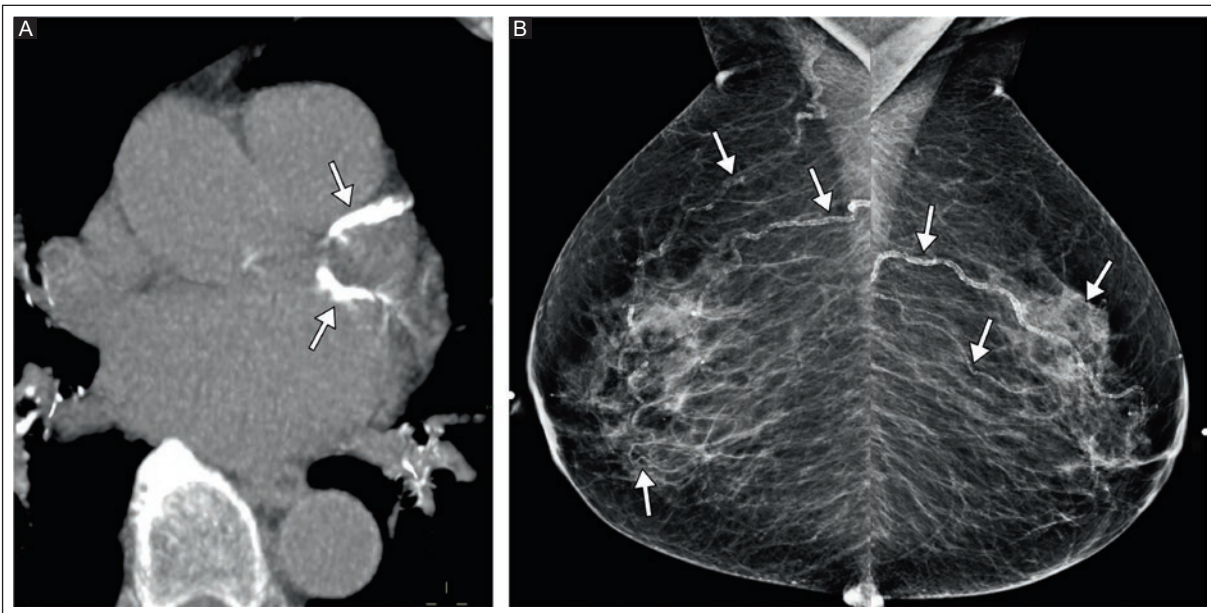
An 81-year-old asymptomatic woman with dyslipidemia. A: MIP reconstruction, axial view of coronary CT calcium score with significant CAC (arrows). AS was 1,494, and AC was severe. B: digital mammography in MLO projection of both breasts shows 3 arteries (3 points) (arrows) with tram-track calcifications (2 points) and vessel length extension greater than two-thirds (3 points) in each breast. The BAC score was 8 in the BAC category of 4 to 12 (significant).
